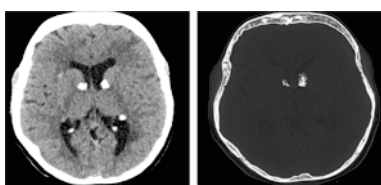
CT, Brain and bone window axial images showing calcified Subependymal nodules along the walls of bilateral lateral ventricles and multiple bony islands in diploic space of frontal bone.
